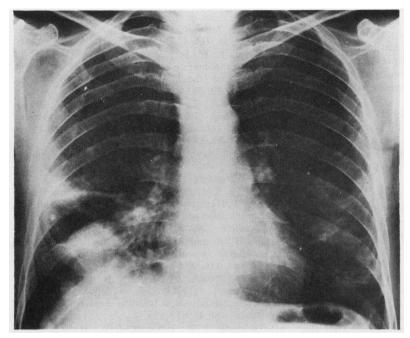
Chest radiograph three weeks later demonstrates shrinkage of the lung abscess in the right middle lobe.
